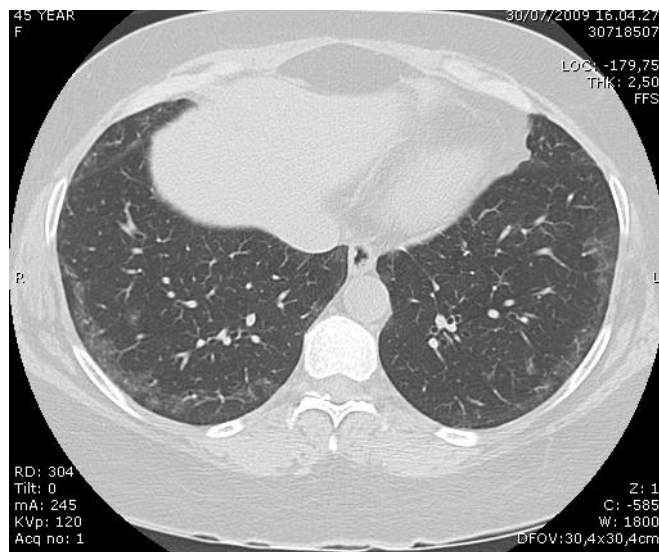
Ground-glass at High Resolution Computed Tomography
